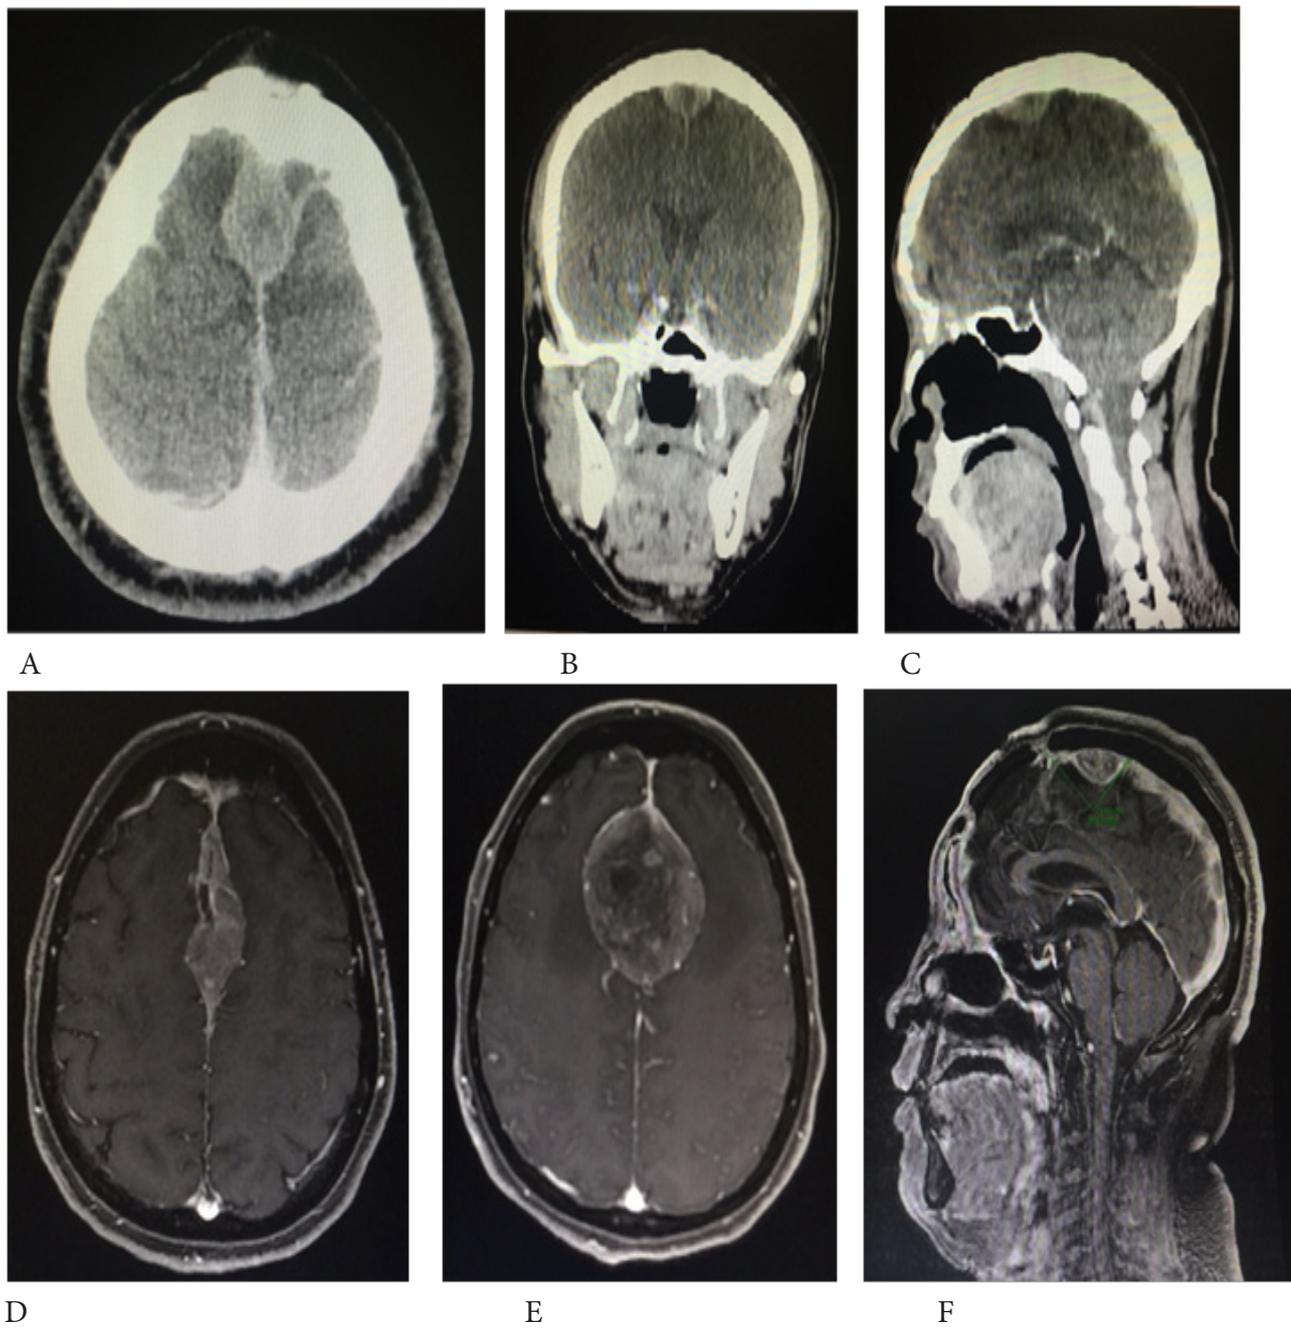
A-C Brain CT scan showing intrasinus metastatic ENB. D-F Contrast enhanced MRI showing metastatic ENB in the middle third of the SSS.
